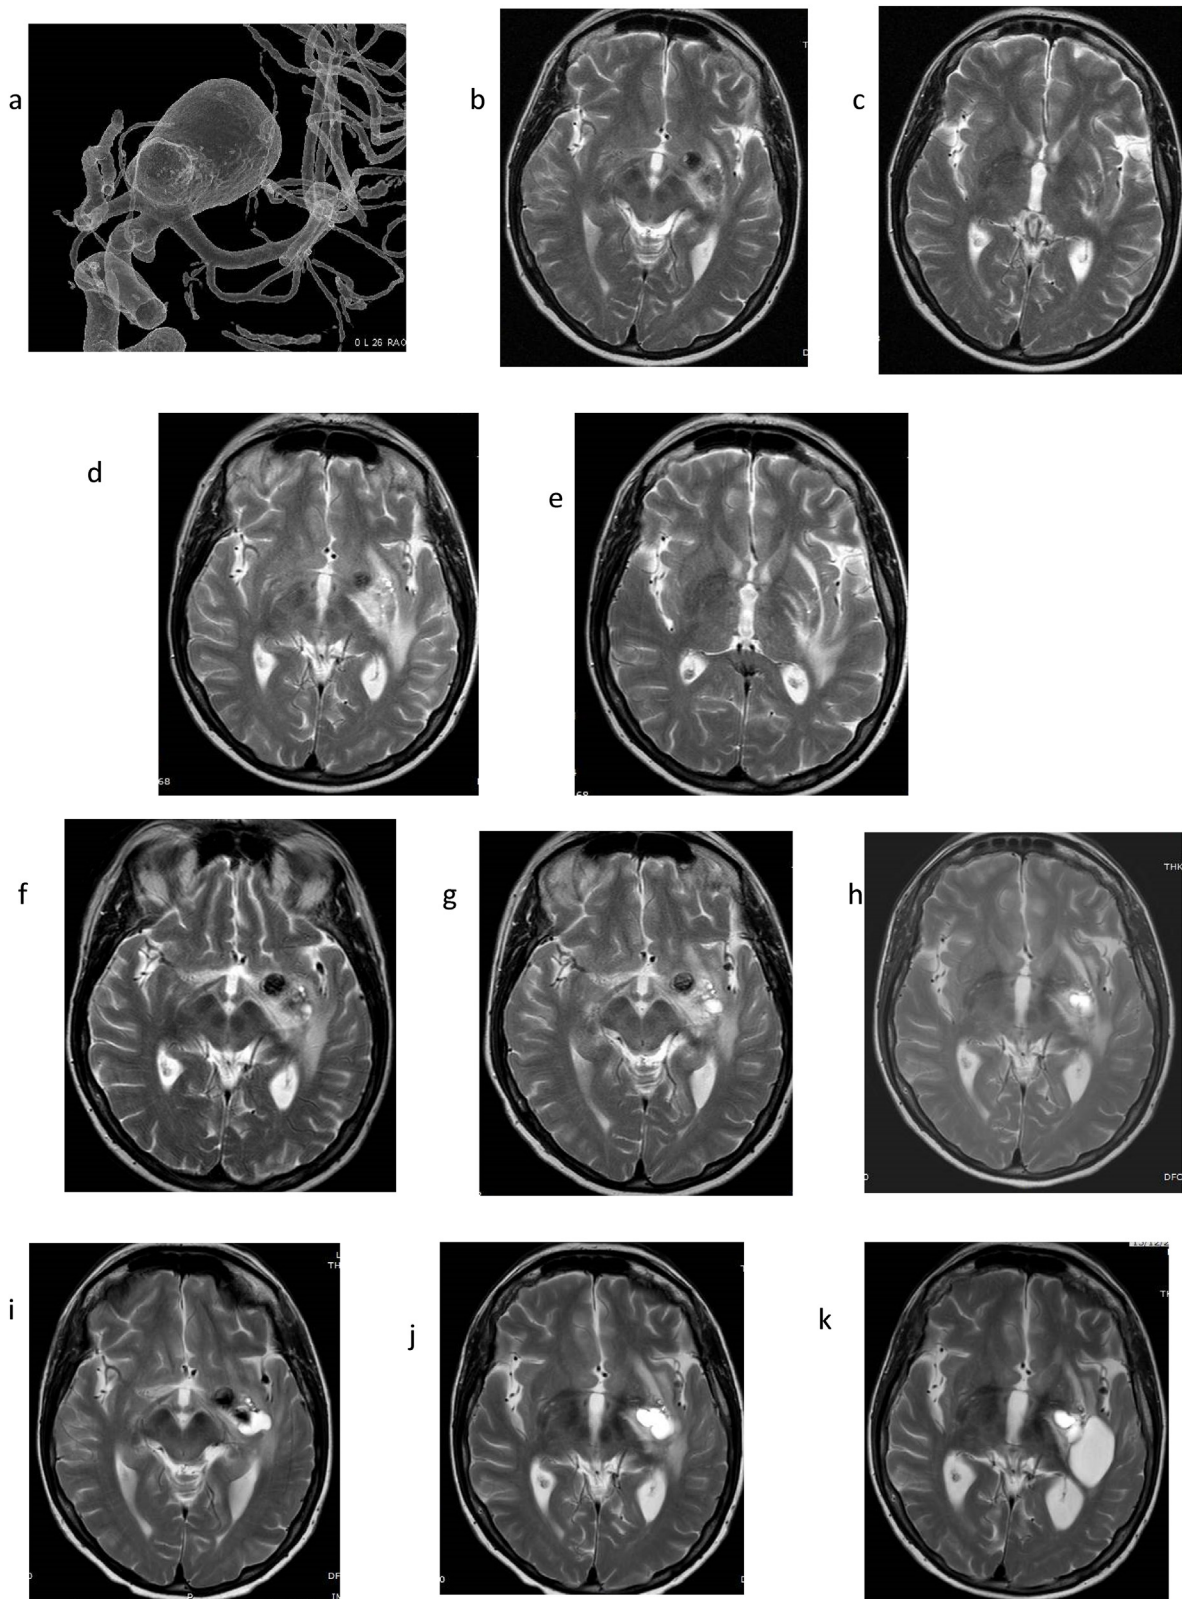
Frontal projection left frontal internal carotid artery 3D DSA demonstrates a giant terminal internal carotid artery aneurysm (a). T2W axial MR images 6 months (b,c), 18 months (d,e), 21 months (f), 27 months (g), 36 months (h), 51 months (i,j) and 119 months (k) after embolisation demonstrate development of progressive oedema and progressive enlargement of cystic spaces.
